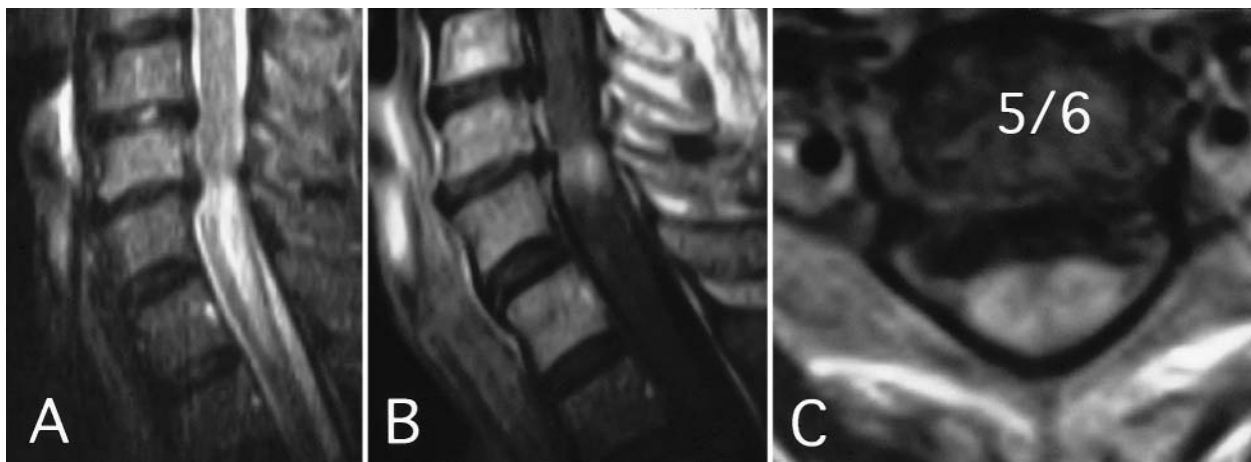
Case 1. Preoperative MR images. A: Sagittal T₂-weighted image revealing a narrowed spinal canal from C4–5 to C5–6. The spinal cord is markedly compressed at C5–6. Intramedullary hyperintensity extends from C5–6 to T-1. B: Sagittal image of T₁-weighted Gd-enhanced image demonstrating intramedullary enhancement of the spinal cord at C5–6. C: Axial T₁-weighted Gd-enhanced image obtained at C5–6 revealing that the white matter of the spinal cord is mainly enhanced.
